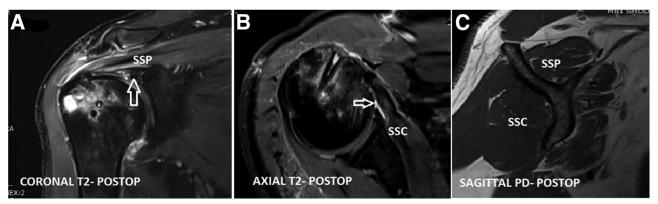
Magnetic resonance imaging postoperative (6 weeks). (A) Coronal T2, repaired supraspinatus with double-row suture bridge. (B) Axial T2, repaired subscapularis with double-row suture bridge. (C) Sagittal Proton Density (PD) image, Goutallier grade, supraspinatus gr 1, subscapularis gr 1.
